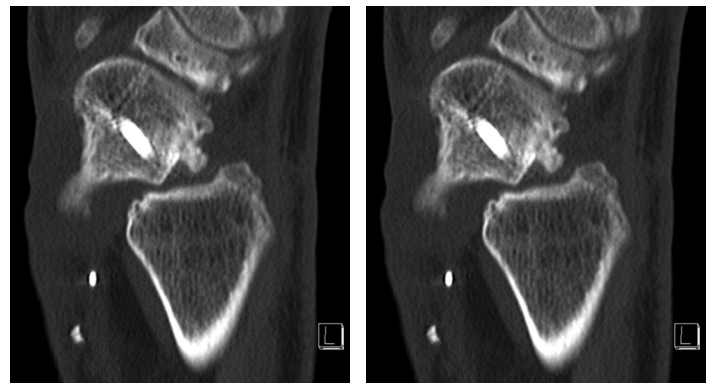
CT right wrist four months status post medial femoral condyle vascularized bone flap to the right scaphoid.
